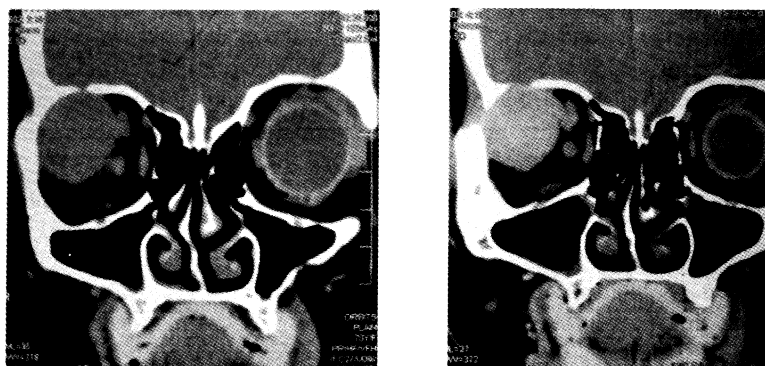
Coronal view of CT scan of orbit
